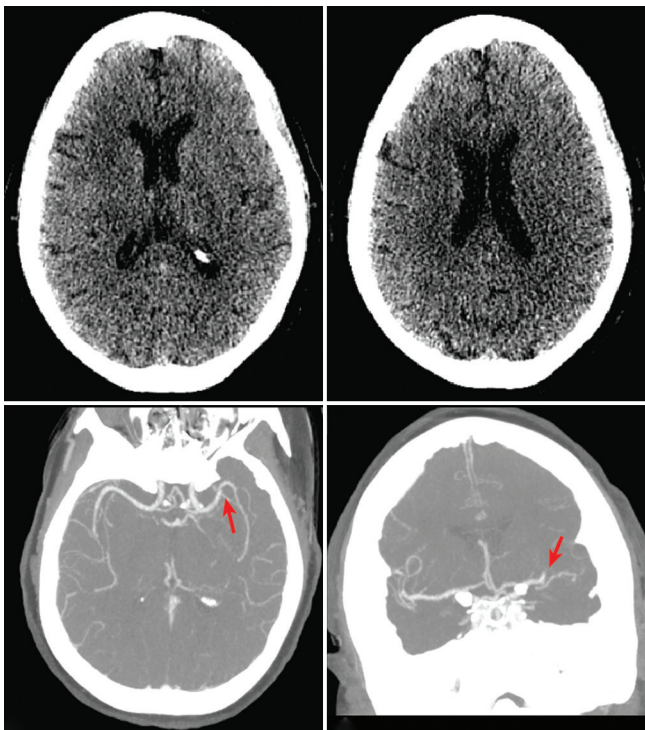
Noncontrast computed tomographic scan of patient one showing no early ischemic changes (panel a and b), consistent with Alberta Stroke Program Early CT
